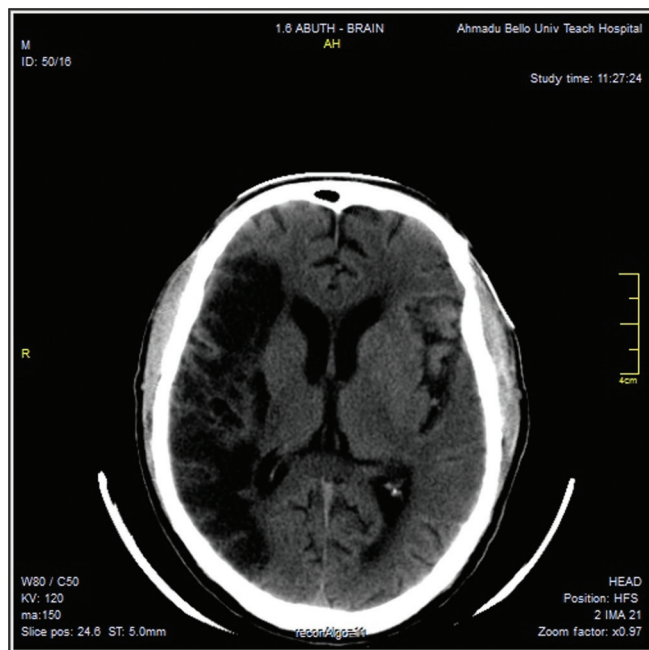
Non Contrast Axial CT image of the brain of a patient showing an extensive infarct involving the right fronto-parietal lobe
